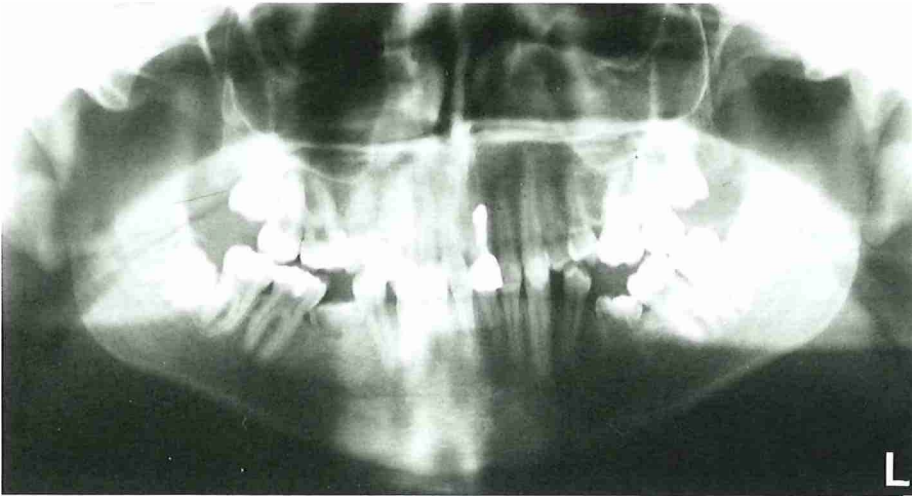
Orthopantomogram of a 14-year-old girl showing secondary retention of both mandibular second deciduous molars without a successor. These molars were removed, because of tilting of the neighbouring teeth and root resorption of the retained molar.
